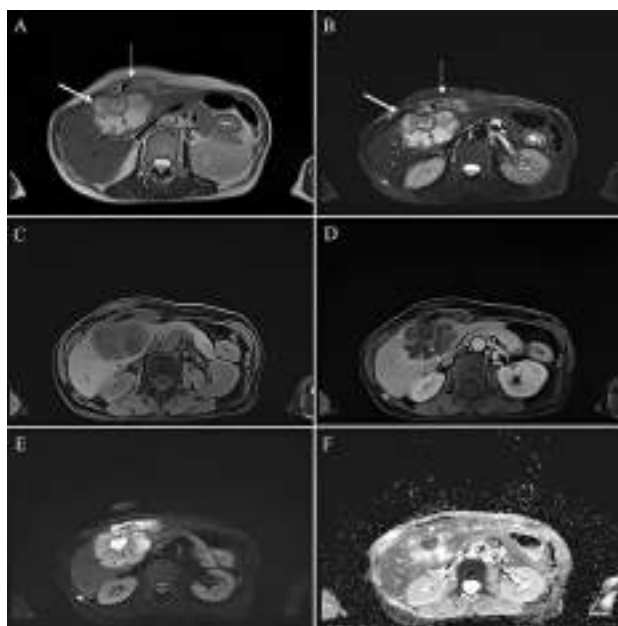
A: MRI demonstrating disruption of the liver capsule and B: connections with the anterior abdominal wall
